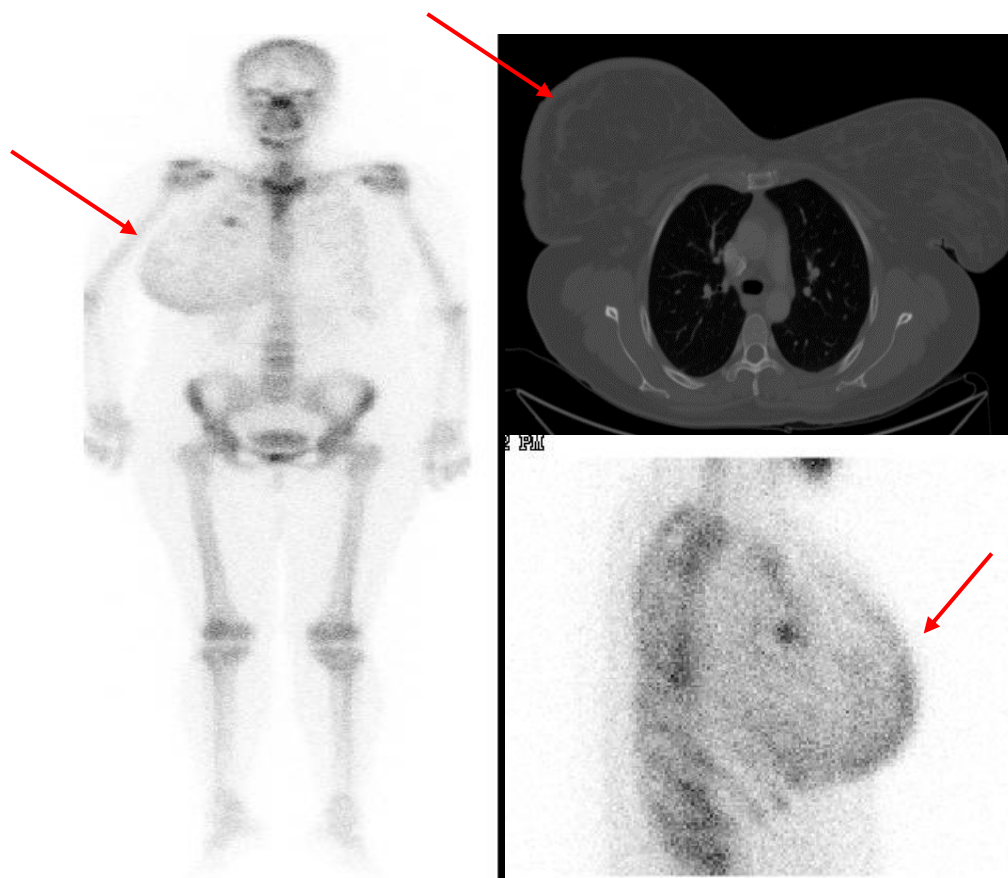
(Left) whole body bone scan in 36-year-old female with right breast cancer shows abnormal increased radiotracer uptake within the soft tissue of enlarged thickened skin as well as an area of uptake corresponding with the breast cancer site. Right breast as appear on CT scan (right upper) with lateral view bone scan (right lower) shows the prominent uptake within the thickened skin of right breast
